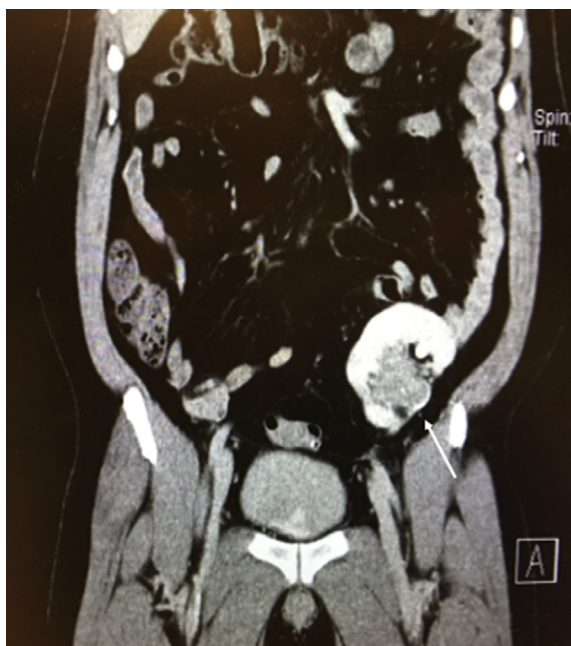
CT intravenous pyelogram demonstrating a distended transplant collecting system with lobulated, hyperdense debris.
